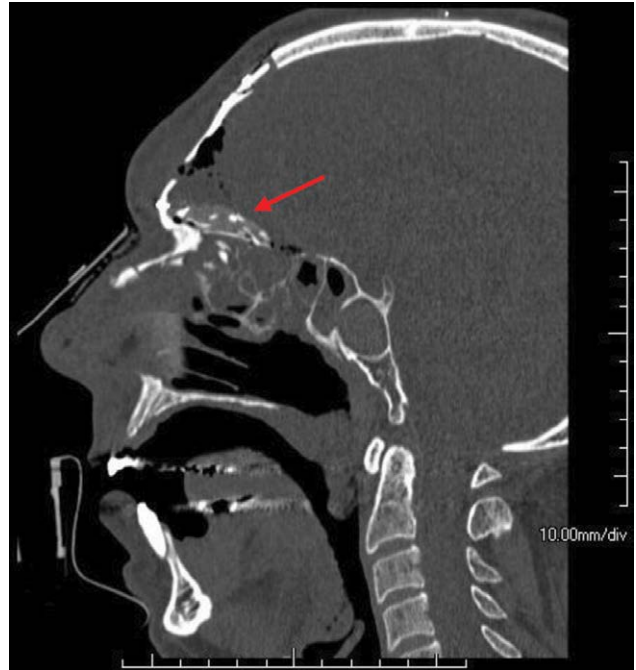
CT scan following cranialization with calvarial bone graft seal. Published with permission from and copyrights retained by Eduardo D. Rodriguez, MD, DDS.
